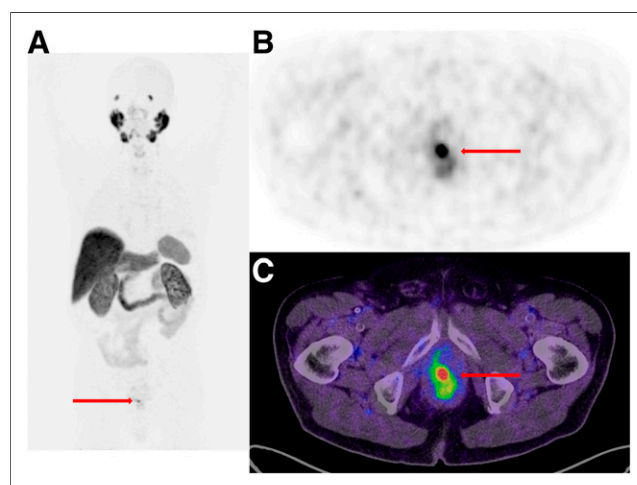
PET/CT of patient with prostate cancer 1 h after injection of ^{18}F -PSMA-1007. Arrows indicate lesions. (A) Maximum-intensity projection. (B) Axial view of pelvic region. (C) Fusion of PET scan and CT scan (pelvic region; axial view).
